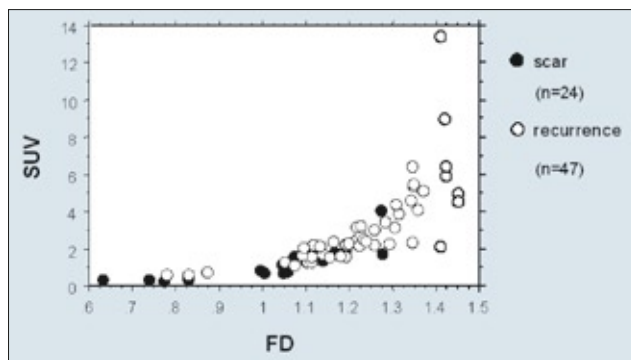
The relationship between fractal dimension (FD) and SUV in postoperative lesions (n=71). The data demonstrate an overlap between recurrent and scar lesions in the low FD and SUV area.
